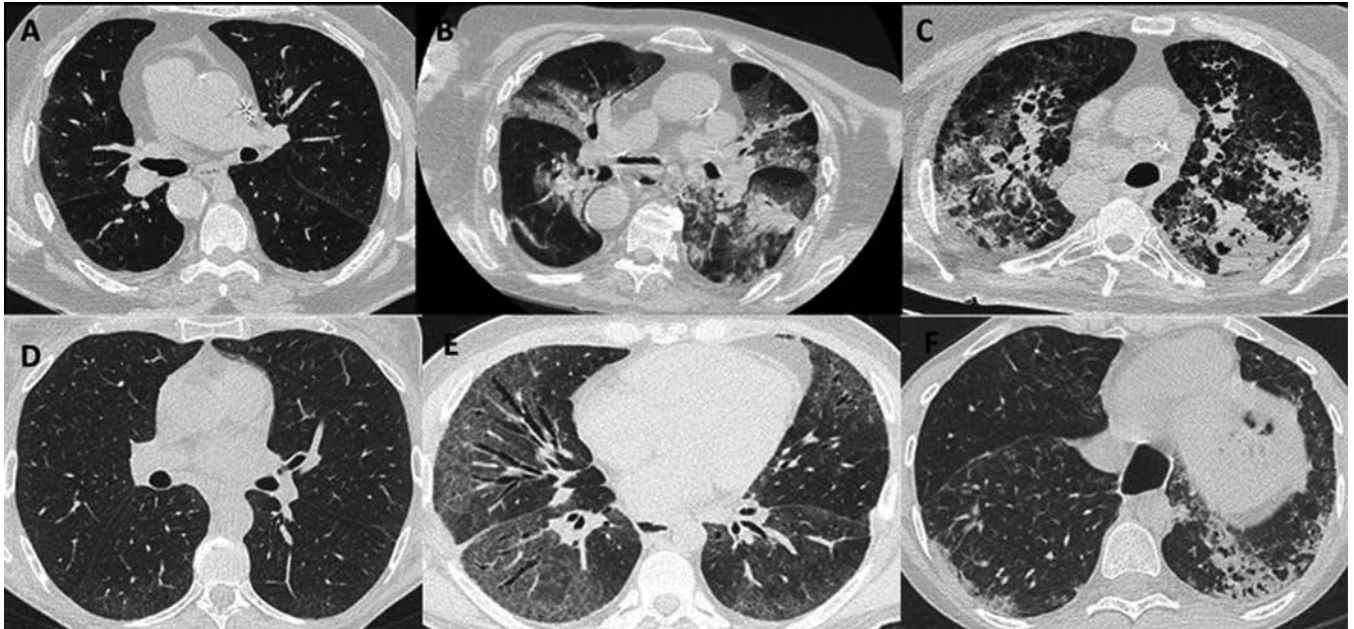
CT scans of (A–C) 3 COVID-19 patients, and (D–F) 3 SSc patients in different phases of disease. (A) Multiple, bilateral GGO, with peripheral predominance in an early phase of disease. (B) Patchy GGO and bilateral consolidations retracting adjacent pleura in a patient in an advanced phase. (C) Wide consolidations, diffuse GGO, and bronchiectasis in a severe case after several days of hospitalization. (D) Typical appearance of ILD in SSc characterized by peripheral GGO with basal predominance. Note in this case the focal GGO in the azygos-esophageal recess and in the contralateral lung next to the descending aorta. (E) Patchy GGO with fine reticulations and traction bronchiectasis bilaterally. Note the unaffected areas next to severely affected areas, similarly to (B). (F) Coarse reticulations in peripheral regions and consolidations along the bronchovascular bundle in the left lower lobe, consistent with SSc-ILD with areas of organizing pneumonia. COVID-19: coronavirus disease 2019; CT: computed tomography; GGO: ground-glass opacities; ILD: interstitial lung disease; NSIP: nonspecific interstitial pneumonia; SSc: systemic sclerosis.
